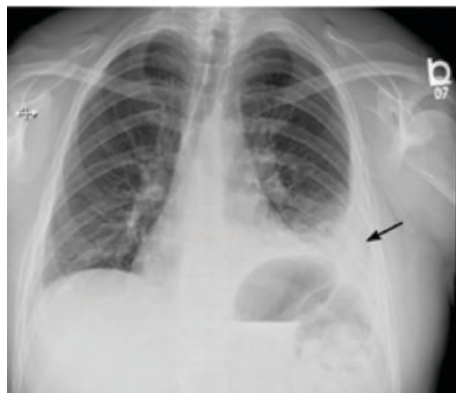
Chest x-ray showed a homogenous opacity in left lower zone with blunting of costophrenic angle
